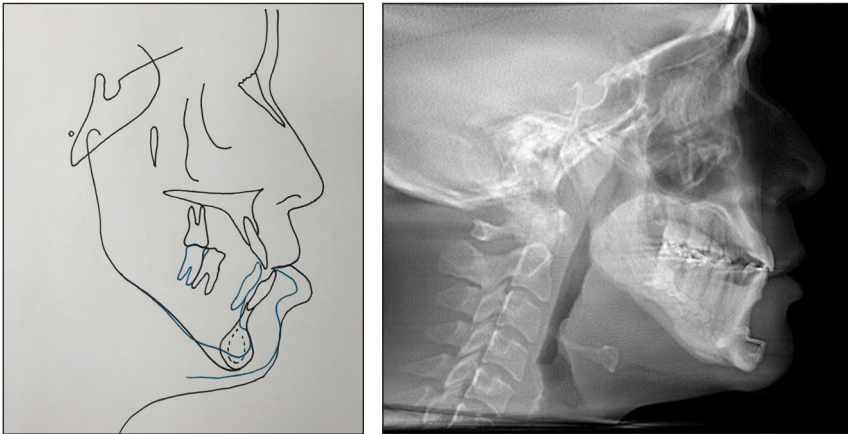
Post-treatment lateral cephalometric radiograph and superimposition
